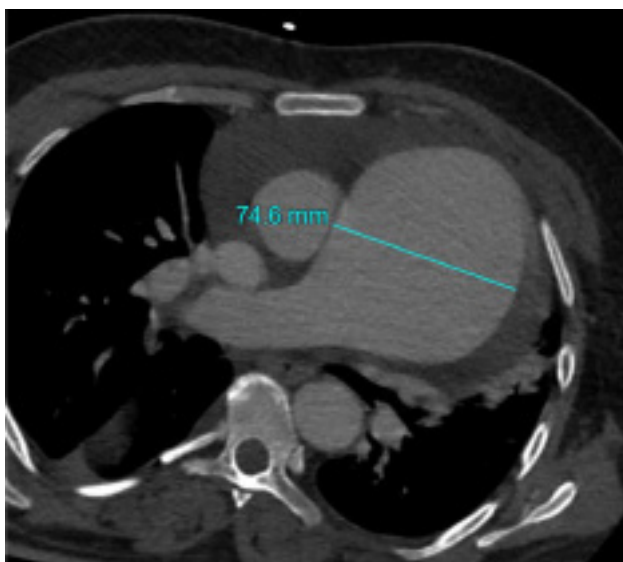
Axial CT image demonstrating a pulmonary artery aneurysm. CT, computed tomography.
